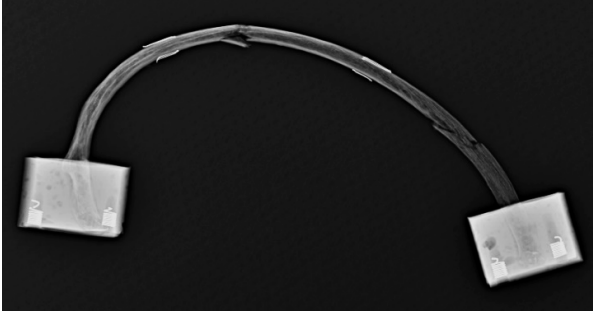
Pair 9 rib (left) and rib+CC (right) post-test x-rays (not to scale)
